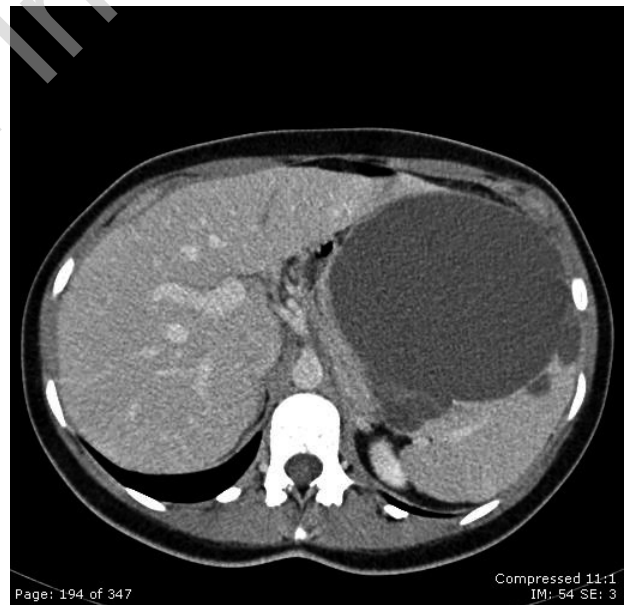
Axial abdominal CT image showing the giant epidermoid cyst of the spleen.
